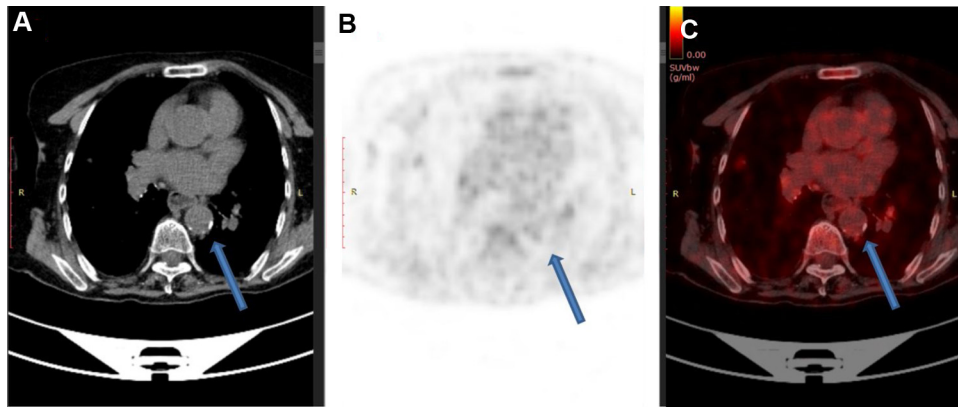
Transaxial 18F-FDG PET/CT images of descending aorta in 55-y-old woman. A. CT image. (B) PET image. C. Fused PET/CT image. 18F-FDG accumulation in atherosclerotic lesion was colocalized with calcification. Arrows indicate calcified lesion.
